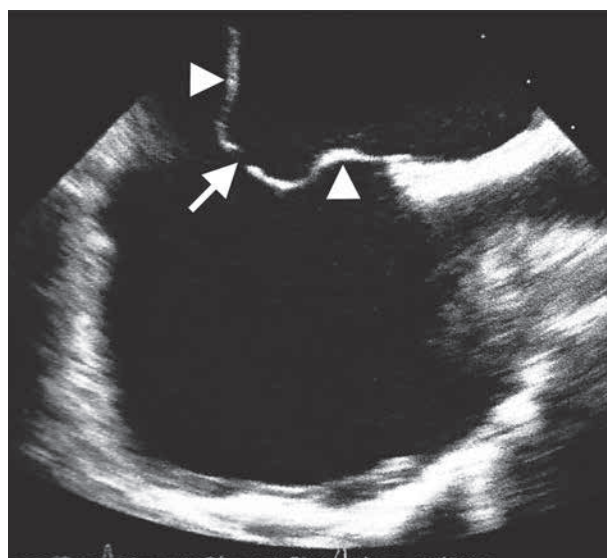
Transesophageal echocardiography disclosed an interatrial septal aneurysm (arrowheads) with three minor septal defects (arrow).
